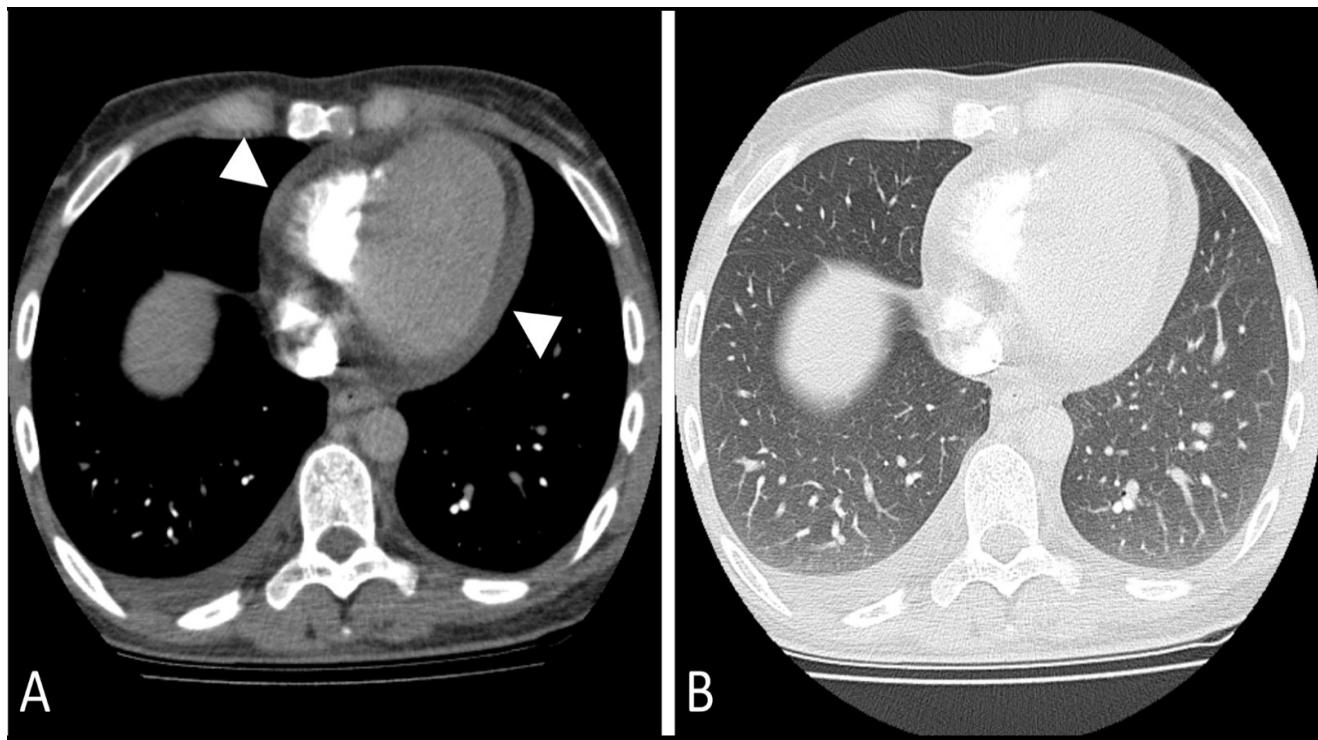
Soft tissue window (A) of pulmonary computed tomography angiography depicts circumferential moderate pericardial (arrowheads) and right-sided pleural effusions. In the lung window settings (B), there were no imaging findings of COVID-19.
